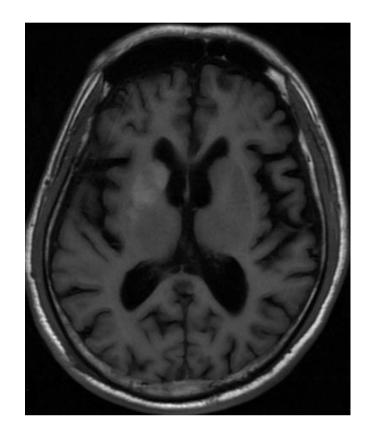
Brain MRI after admission showed right basal ganglion T1-hyperintensity with neuronal loss, suggestive of chorea associated with non-ketotic hyperglycemia
